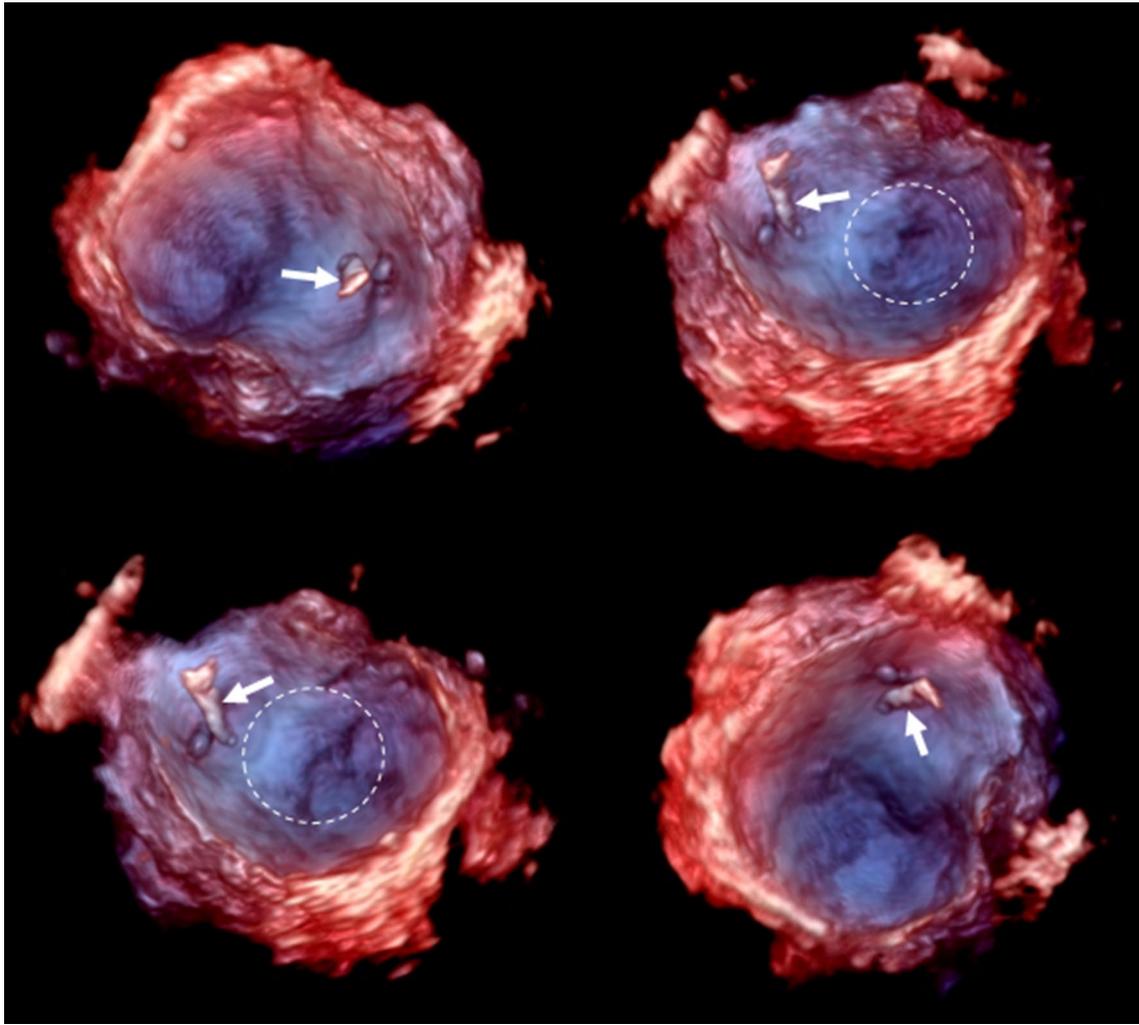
The real-time three-dimensional images from multiple angles of the cystic lesion in the pancreas obtained with the transesophageal echocardiography probe. Internal features of the cystic lesion are clearly demonstrated with uneven wall (circle) and the thickened septum (arrow)
